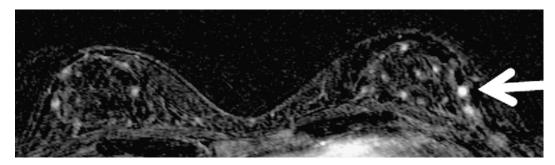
Foci in a high-risk patient on annual screening magnetic resonance imaging (MRI). Axial subtracted gadolinium-enhanced image, demonstrating multiple small enhancing foci in both breasts; the most prominent is seen in the left lateral breast (arrow). All foci remained stable on MRI for several years.
